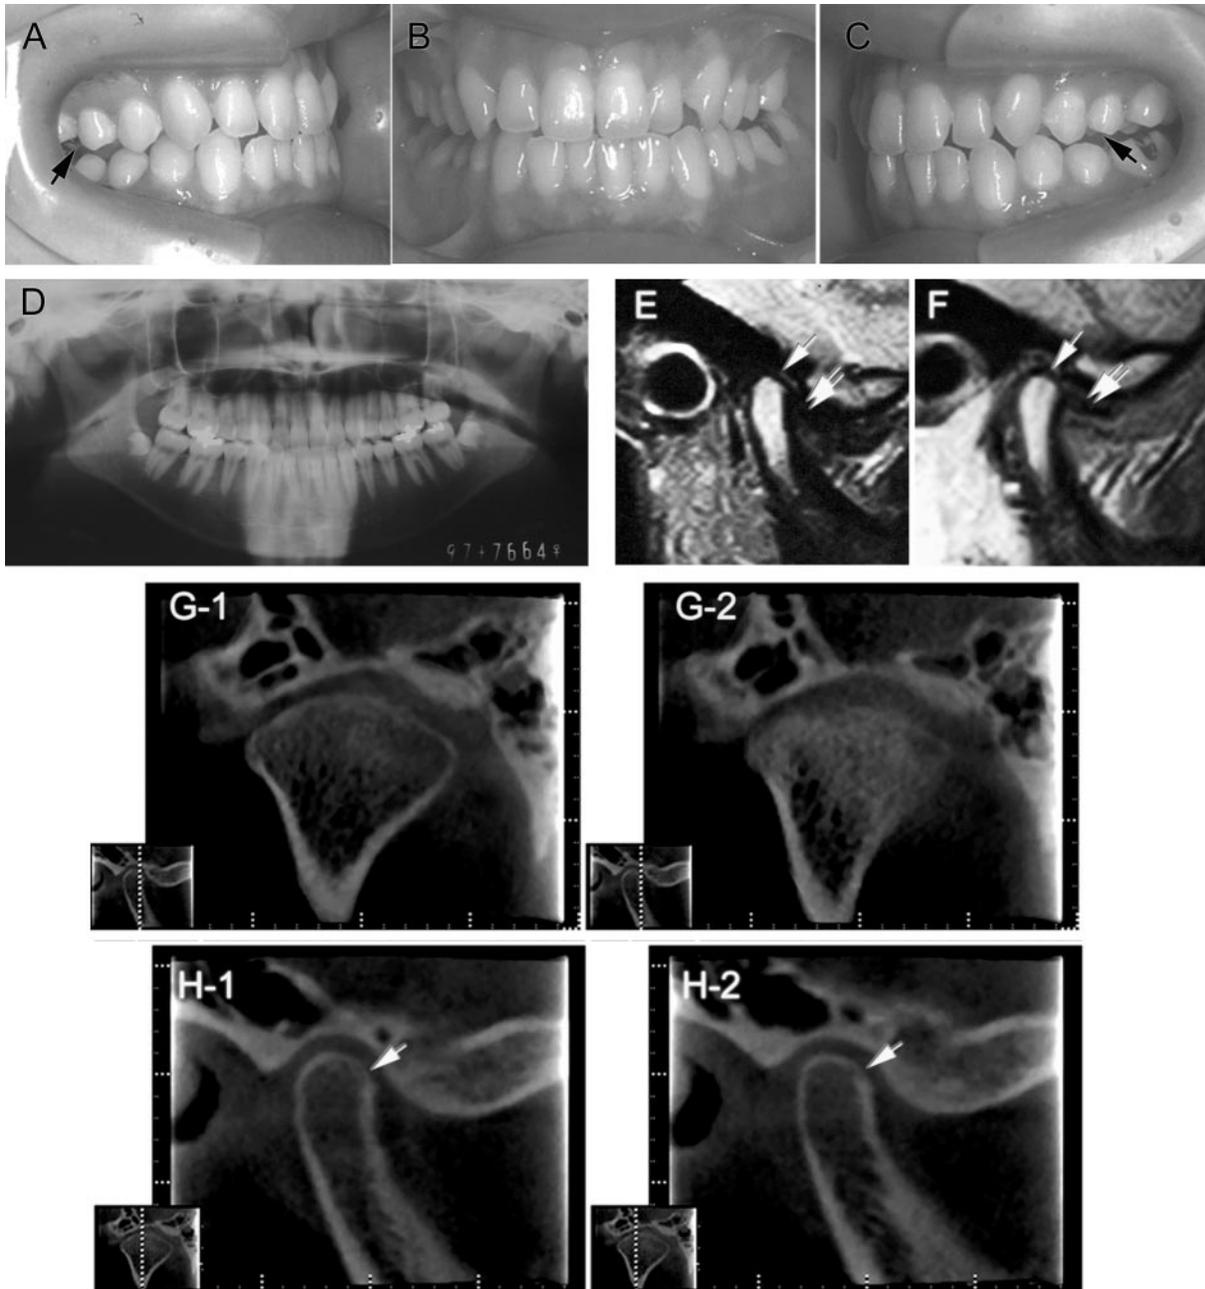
Case 3: (A–C) Oral photograph. (D) Panoramic radiography. (E) T1 magnetic resonance image (MRI) of left temporomandibular joint (TMJ). (F) T2 MRI of left TMJ. Single arrows indicate the cortical bone of TMJ, and double arrows indicate the temporomandibular disk. (G 1,2) Frontal 3DX images of left TMJ in the first visit. (H 1,2) Sagittal images; the single arrow indicates bone erosion.
